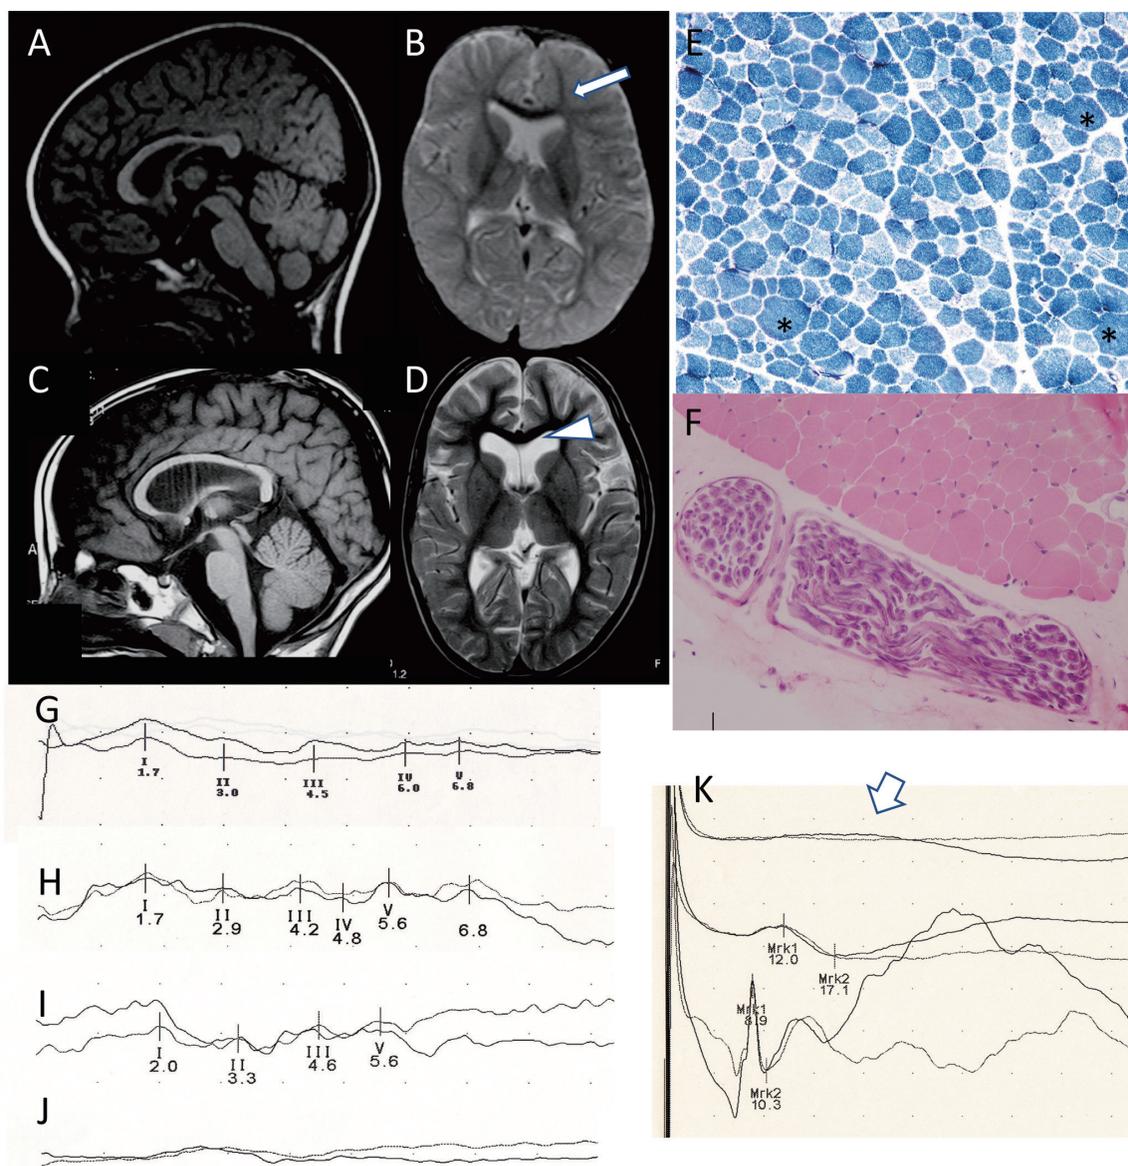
Brain magnetic resonance imaging (MRI) of patients 1 (A, B) and 2 (C, D), muscle biopsy of patient 1 (E, F), and electrophysiological study of patient 2 (G-K).
